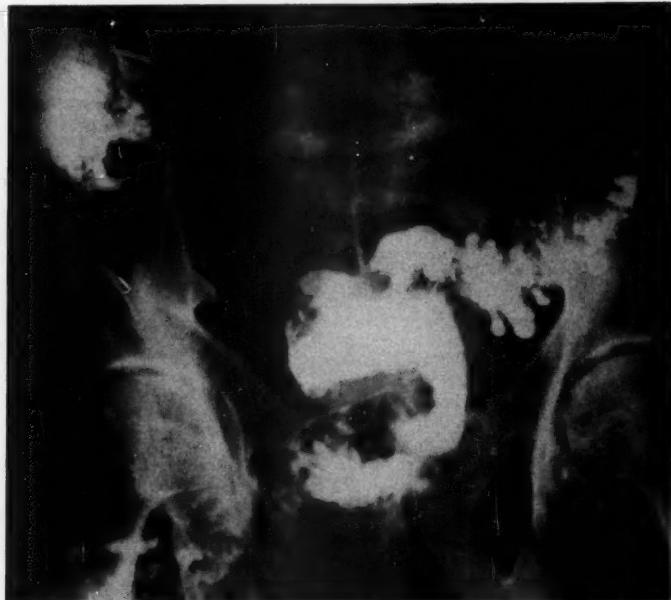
The roentgenologist diagnosed diverticulitis of the sigmoid with perforation and obstruction.
